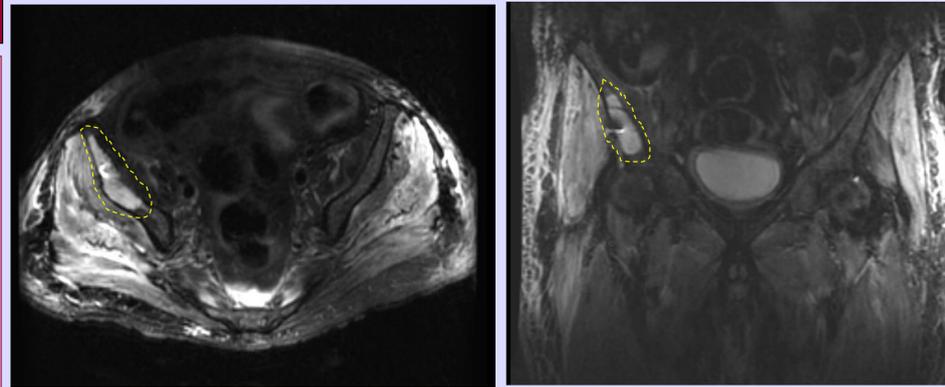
Magnetic resonance imaging of the pelvis reveals a destructive lesion measuring 7 x 5 x 2 cm in the right ilium above the right acetabulum
